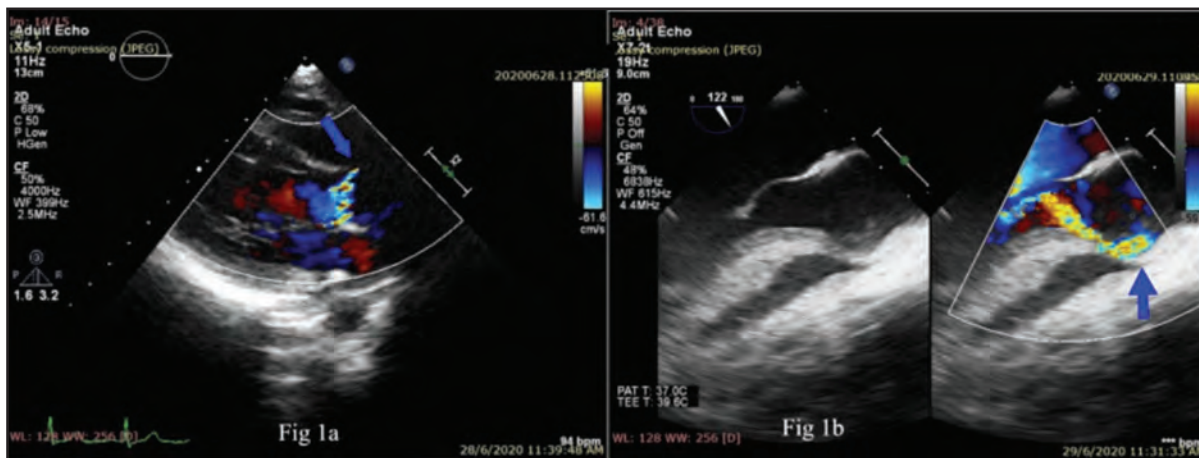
Echocardiogram of the patient on long axis view (1a) showing skewed jet from patient with continuous murmur variously diagnosed as BAV and AR, AR secondary to rheumatic fever. Transoesophageal echo revealing left AVT (1b), which can be seen especially with colour Doppler, appearing above the coronary sinus and then coursing beside it before entering the left ventricle just below the aortic valve (arrow). AVT=aorto-ventricular tunnel, AR=aortic regurgitation, BAV=bicuspid aortic valve.
